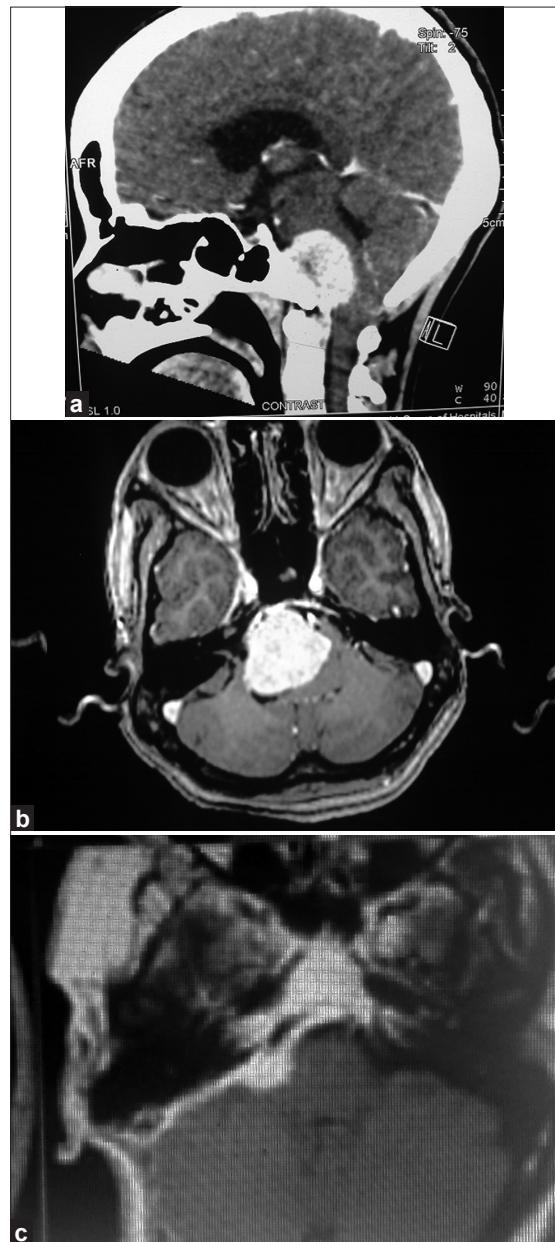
Ventral foramen magnum meningioma with post op MRI s/o residual adherent to cranial nerves
